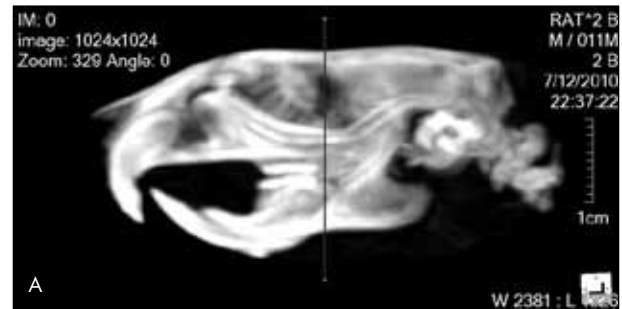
(A) The orientation of the coronal slice taken. (B) The coronal CT slice taken 0.5 mm distal to the third maxillary molar with the occlusal plane horizontal, displaying the anatomical points used for analysis. (see Table I for definitions of all points)
